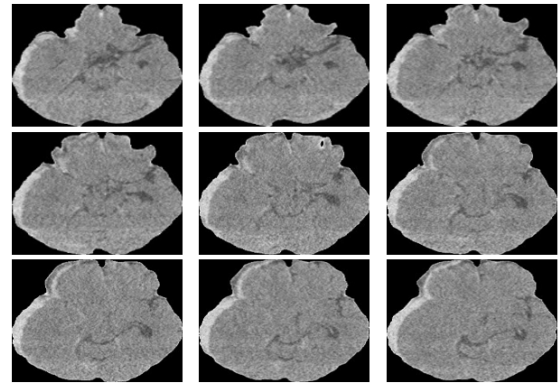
Samples of CT brain slices (after pre-processing step from 3D to 2D)
